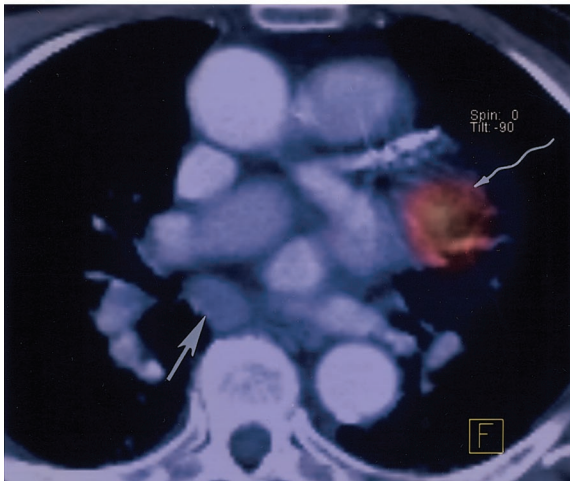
(17) Melanoma in a 33-year-old man. The extent of disease was evaluated with FDG PET–CT. Axial (a) and sagittal (b) fused FDG PET–CT images show focal hypermetabolism in the left paraspinal soft tissue (arrow in a) and in T8 (arrow in b), findings consistent with metastases. CT showed only subtle areas of decreased attenuation. Arrowheads in a = misregistration artifact due to cardiac motion. (18) Non–small cell lung carcinoma in a 78-year-old man with enlarged hilar and mediastinal lymph nodes. FDG PET–CT was performed for staging. Axial fused FDG PET–CT image shows an enlarged subcarinal node without abnormal metabolism (straight arrow), which was reactive. The metastatic left hilar node is FDG avid (wavy arrow), as was the primary tumor. (19) Large B-cell lymphoma in a 74-year-old man. FDG PET–CT was performed for staging. Sagittal fused FDG PET–CT image shows wedge compression deformity of L4 with moderate hypermetabolism (arrow), which was confirmed at biopsy to be metastasis. (20) Large cell lung cancer in a 54-year-old woman. Axial fused FDG PET–CT image shows hypermetabolism within a lung mass (arrow) and distal drowned lung (arrowheads). Precise localization of a tumor within a larger mass helps direct intervention such as biopsy.
